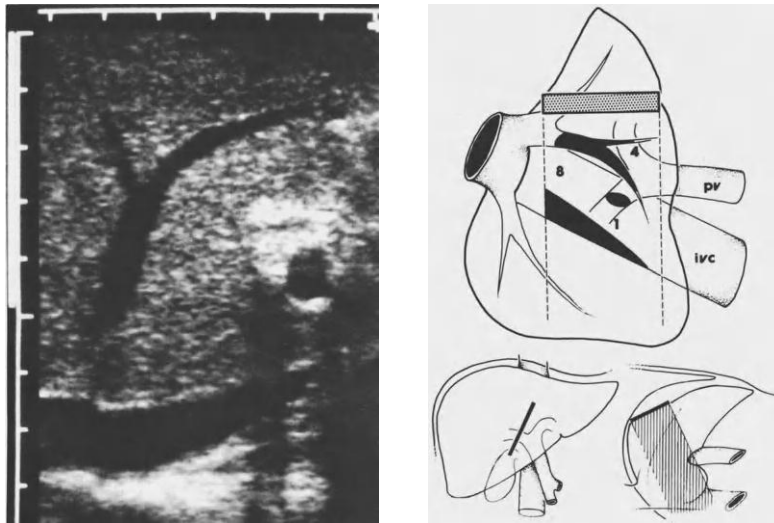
Operative ultrasound anatomy: the main scissura and the middle hepatic vein (*Castaing et al., 1985*).
